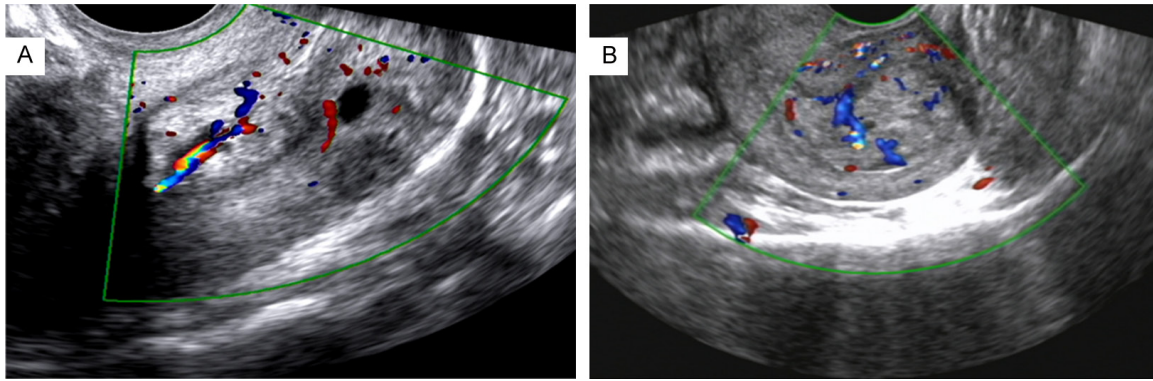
Typical ultrasonic images of benign and malignant groups. A: Benign Endometrial Polyps - The ultrasonic image displays endometrial thickening with a uniform echo of the lesion and a clear boundary between the endometrium and the myometrium. The area of interest is highlighted in a green box. B: Malignant Endometrial Carcinoma - The ultrasound features include abnormal thickening of the endometrium, uneven echo of the lesions, and an unclear boundary between the endometrium and myometrium. The typical area is marked in a green box.
